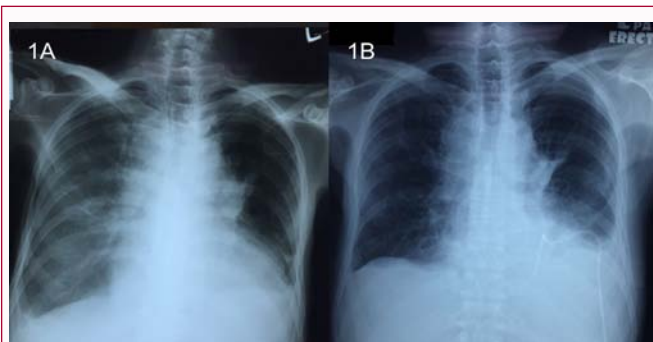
A) Chest radiograph showed enlarged cardiac silhouette. B) Chest radiograph showed post pericardiocentesis and pigtail catheter *in situ*.
